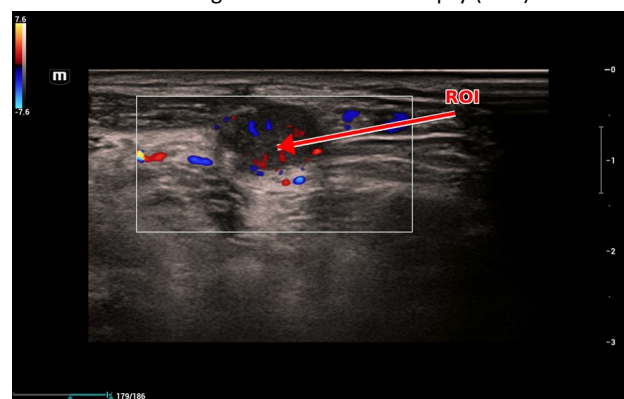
Representative color Doppler ultrasound image of a suspicious lymph node. The arrow indicates the solid target ROI while Doppler imaging demonstrates adjacent and intranodal vascular signals.
